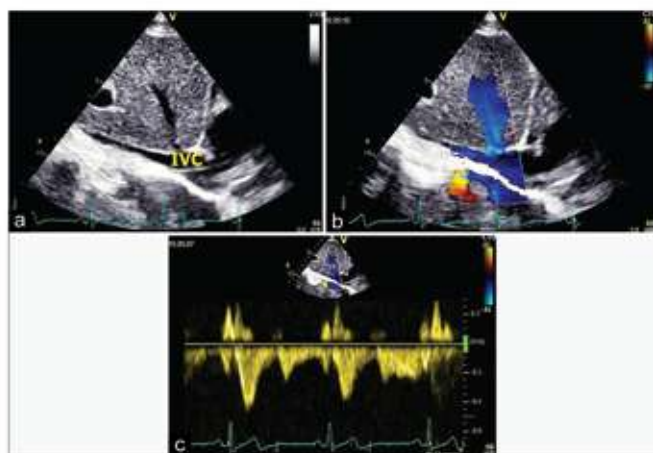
(a) A subcostal view of the inferior vena cava in long axis, (b) color flow across the hepatic vein entering into the inferior vena cava, (c) pulsed-wave Doppler signal across the hepatic vein. IVC-inferior vena cava
